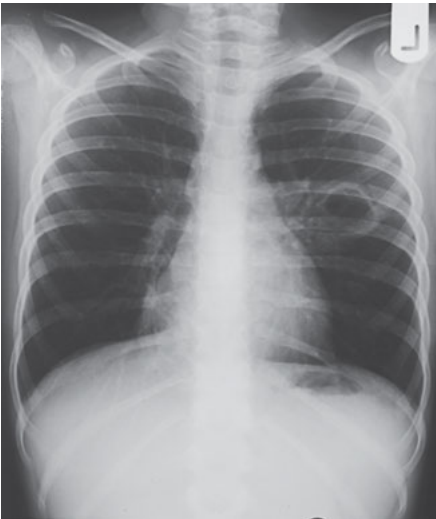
Chest X-ray of a 7-year-old girl with an intrapulmonary bronchogenic cyst in the left lung. The lesion was found incidentally, and the girl was asymptomatic.
